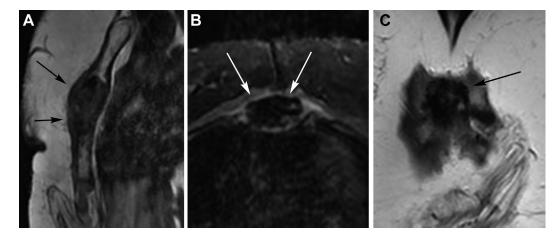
(A-C): (A) Sagittal T2 weighted, (B) axial T2FS, and (C) coronal T2-weighted MR images show a hypointense mass (arrows) arising from the superior sternal body, with extension into the inferior margin of the manubrium, with perilesional edema.
